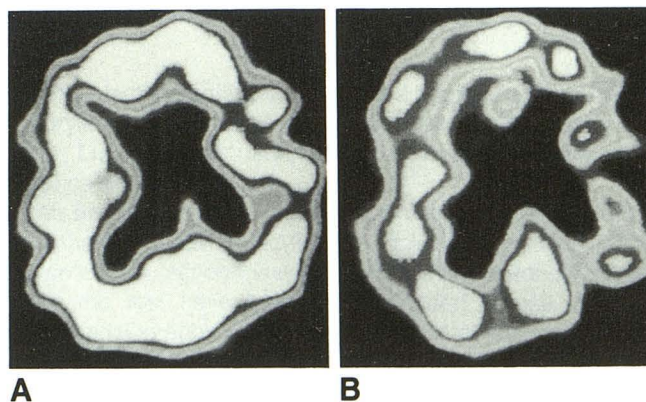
A, Baseline ^{99m}Tc-HMPAO SPECT image of patient discussed in Case Report section (patient 3, Table 1) shows a 6% reduction in perfusion in left middle cerebral artery (MCA) distribution compared with perfusion in right MCA distribution.
